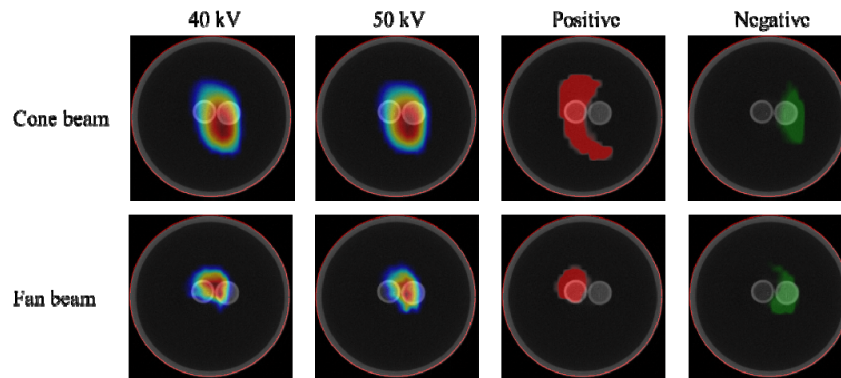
Tomographic ($z = 1.1$ cm) XLCT and PC2-XLCT results. Images in the first row were reconstructed from cone-beam imaging, while images in the second row were from fan-beam imaging.
